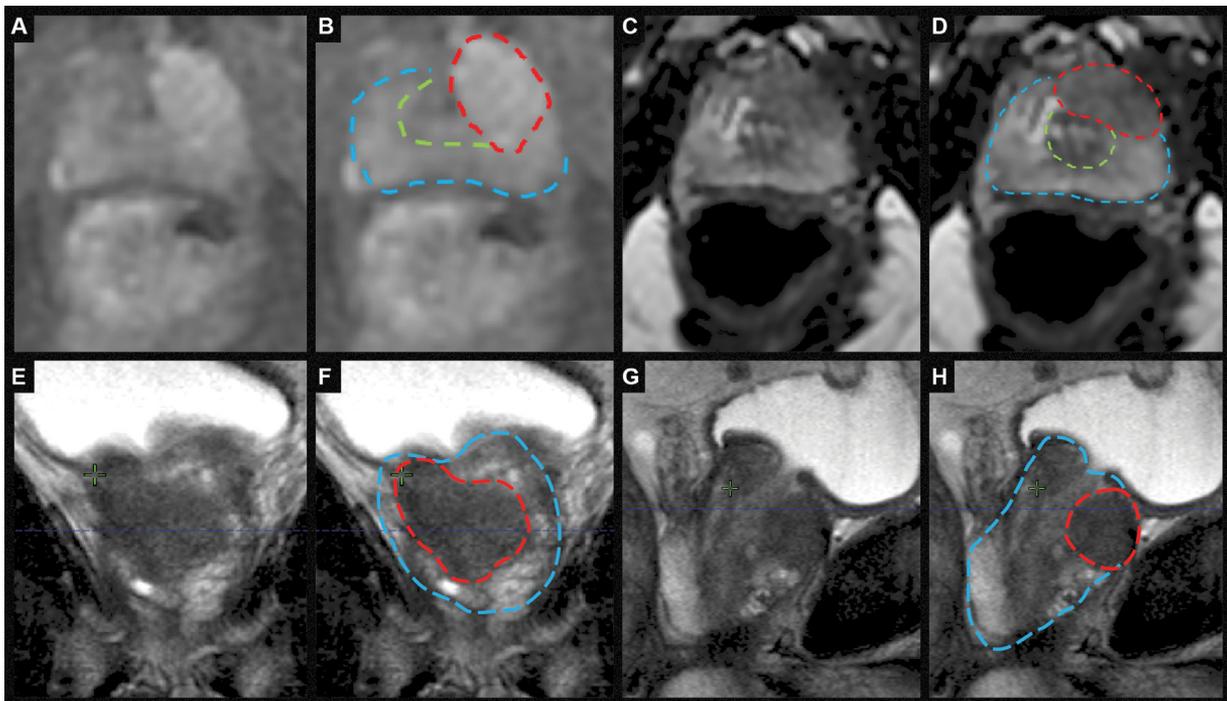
Tumor definition by multiparametric MRI. (A) Dynamic contrast enhanced axial MR image demonstrating an anterior T3 lesion in a young favorable risk patient. (B) Prostate in blue, transition zone in green, and tumor in red contoured. (C) An axial image of the prostate using a diffusion sequence demonstrating the same lesion. (D) Contours shown for panel C. (E) Coronal T2 sequence demonstrating an extensive unsuspected transition zone tumor (charcoal smudge sign). (F) Contours shown for panel E. (G) Sagittal view of the T2 showing the proximity to the bladder neck. (H) Contours shown for panel G.
